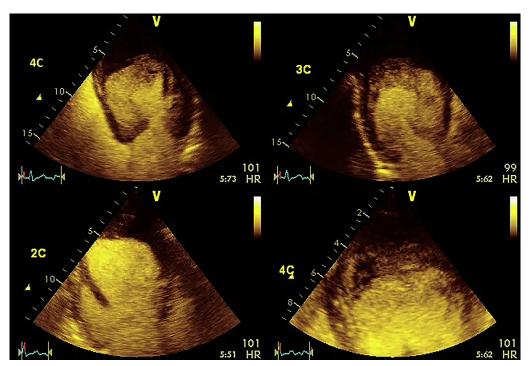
Transthoracic echocardiogram with microbubble injection shown in a quad screen. Apical four-chamber (4C), apical long-axis (3C), and apical two-chamber (2C) images are shown. The *lower right* image is a close-up view of the apical 4C image. A filling defect is seen in the apex of the left ventricle.
